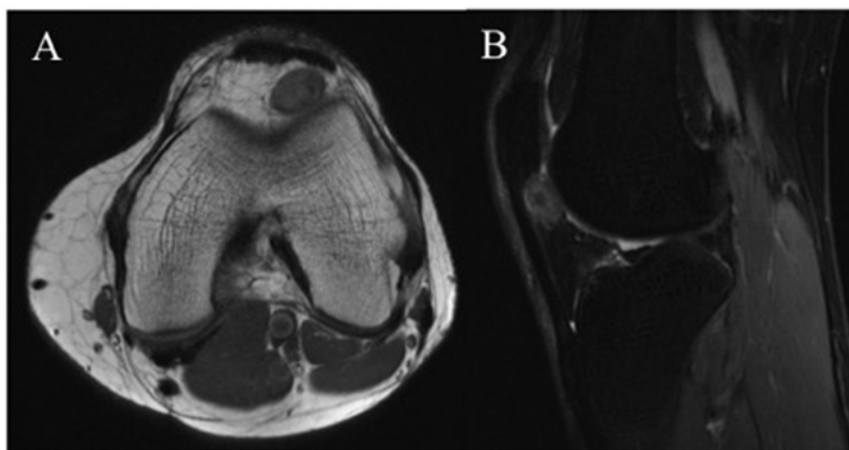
Magnetic resonance imaging in the axial (A) and sagittal (B) plane demonstrating the low signal nodule on the T1 weighted images. It is well circumscribed and adjacent to the patella tendon. The size was 1.3×0.9 cm.
